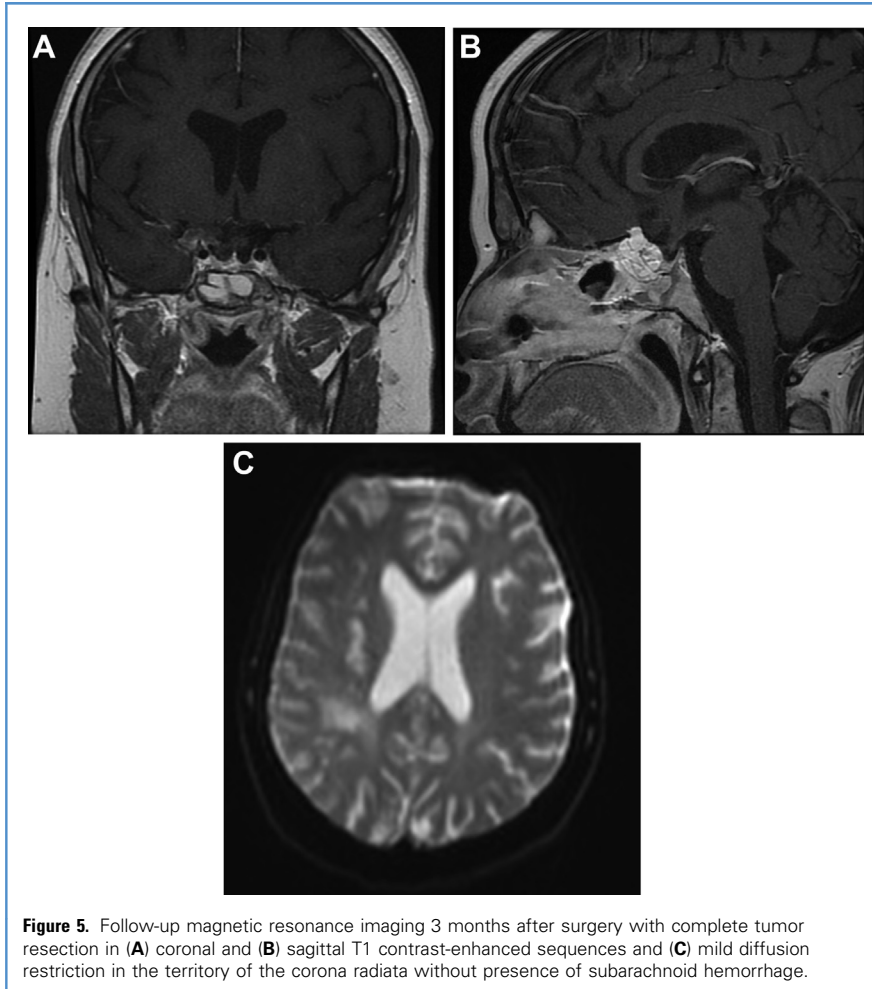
Follow-up magnetic resonance imaging 3 months after surgery with complete tumor resection in (A) coronal and (B) sagittal T1 contrast-enhanced sequences and (C) mild diffusion restriction in the territory of the corona radiata without presence of subarachnoid hemorrhage.
